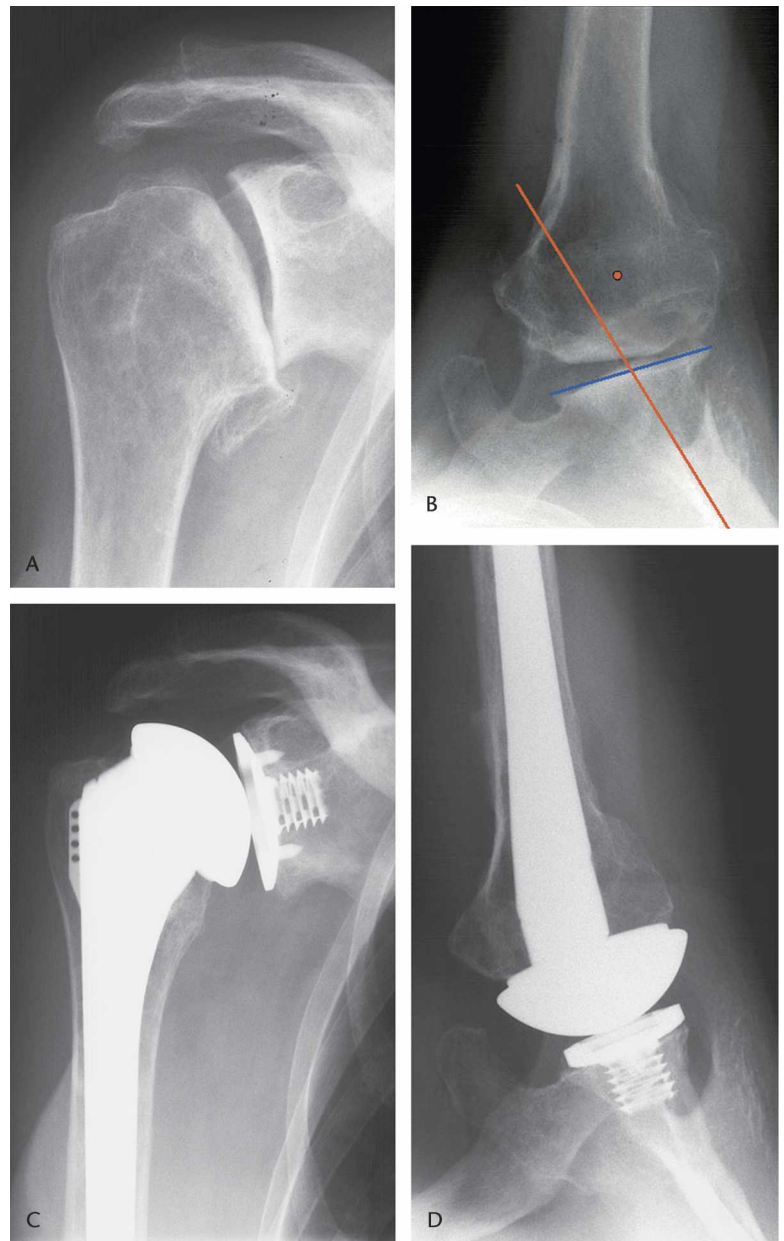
(A) A true AP radiograph shows a patient with severe OA. (B) The axillary view shows posterior glenoid wear and posterior decentering of the humeral head. (C) The true AP radiograph control taken 2 years postoperatively shows a centered humeral head in the coronal plane. (D) The axillary radiograph control taken 2 years postoperatively shows a recentered humeral component.
